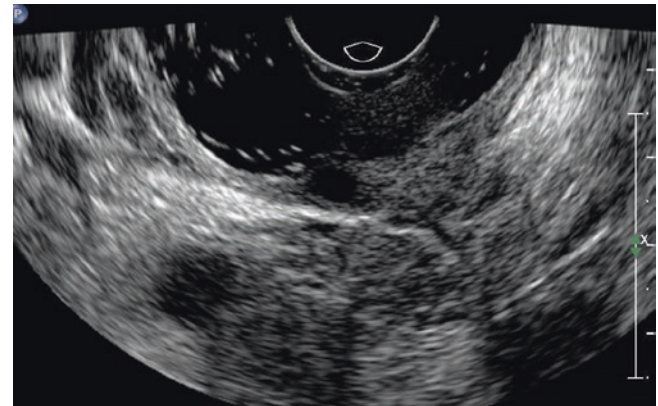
Transvaginal transverse image shows posterior vaginal fornix thickened, with round cystic anechogenic areas. The vagina was distended by ultrasound gel
